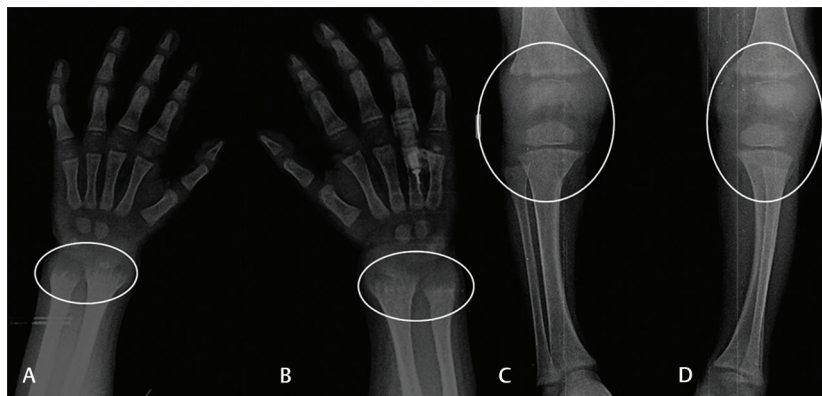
Frontal radiographs of both wrists and legs show typical features of rickets. (A, B) Cupping (concavity), fraying (indistinct margins), and splaying (widening) of distal metaphyses of radius and ulna bilaterally (encircled). (C, D) Similar changes involving the lower end of bilateral femora and upper ends of tibia and fibula.
